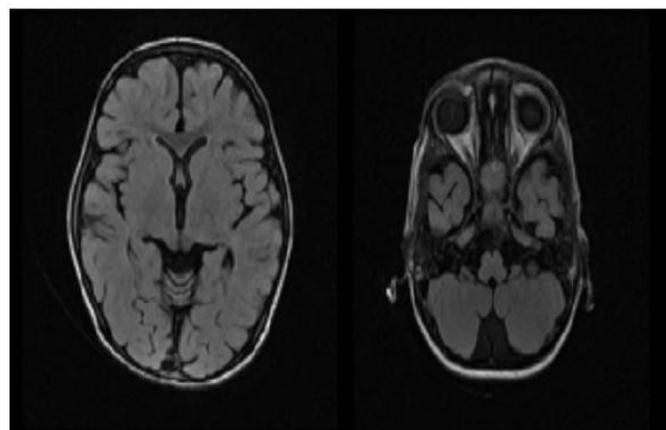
MRI Brain showing diffuse cerebral atrophy
